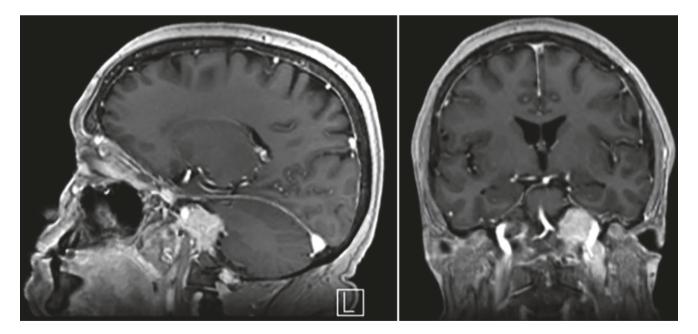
Preoperative MRI, (Left) coronal and (Right) sagittal
